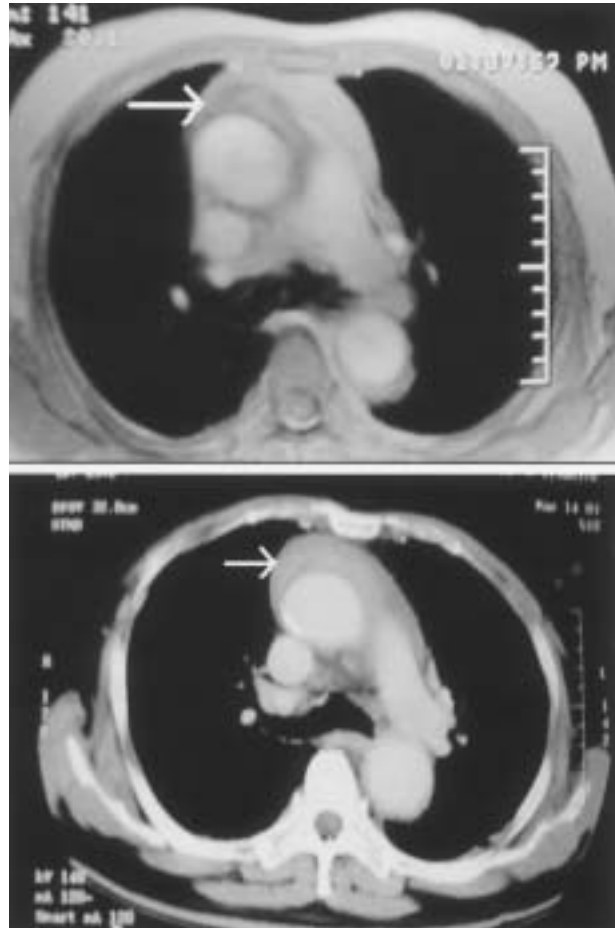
Contrast-enhanced CT revealing an extensive intramural hematoma from the proximal aorta to the level of T11 vertebra.
